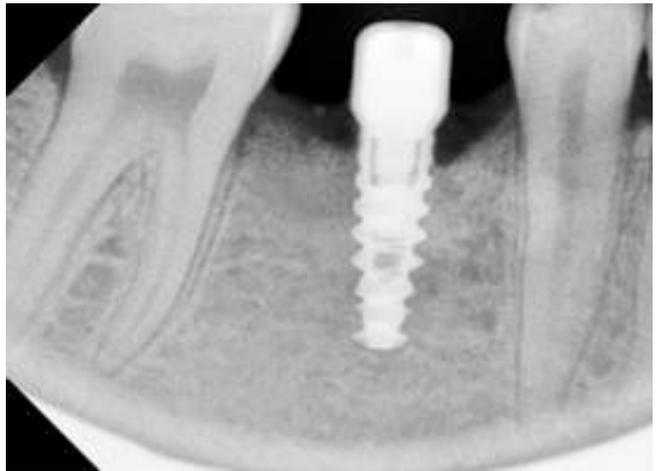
Post op radiograph after 4 months of implant placement.
